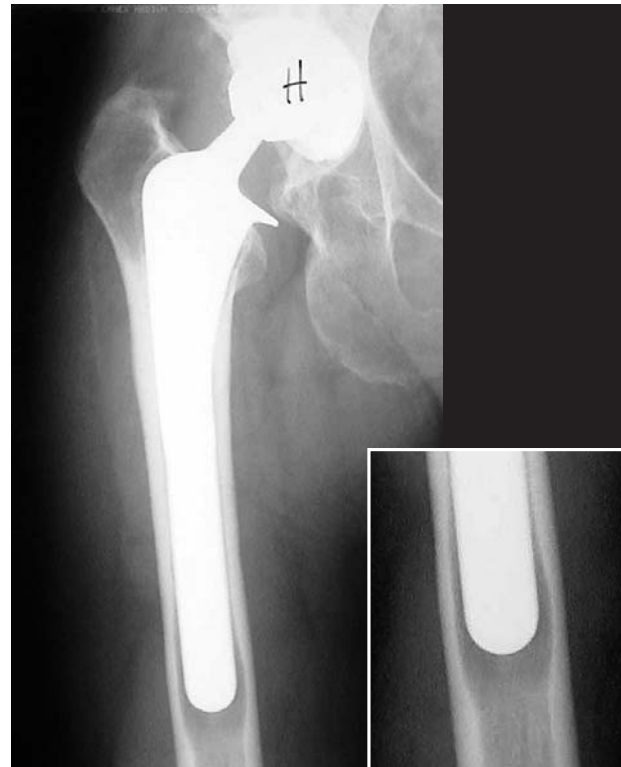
Harris-Galante stem showing moderate distal osteolysis. Radiographically, the stem is otherwise well fixed.
